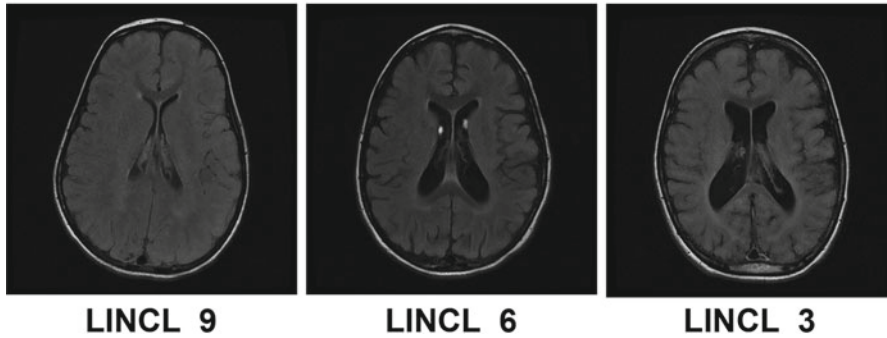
Examples of MRI images at different stages of LINCL disease progression. The MRI demonstrates increasing volumes for the CSF filled ventricles and decreasing brain gray matter as disease progresses from the score of 9 to 3 on the Weill Cornell LINCL rating scale [52]
